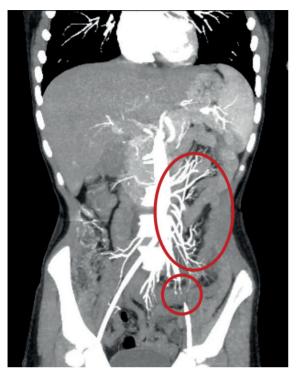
Computed tomography angiography showing increased mesenteric vascularization at the level of the ileal loops in the left lower quadrant (upper ellipse) and contrast filling defect in the left iliac artery (lower circle).
